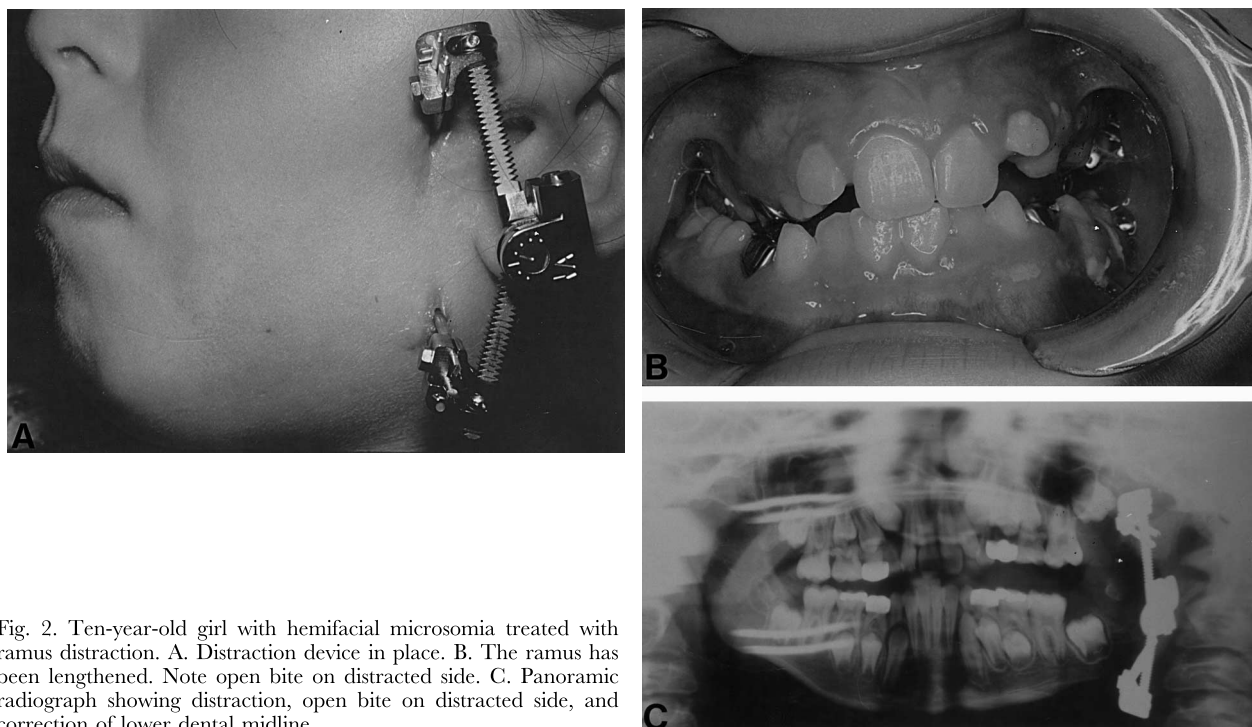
Ten-year-old girl with hemifacial microsomia treated with ramus distraction. A. Distraction device in place. B. The ramus has been lengthened. Note open bite on distracted side. C. Panoramic radiograph showing distraction, open bite on distracted side, and correction of lower dental midline.
